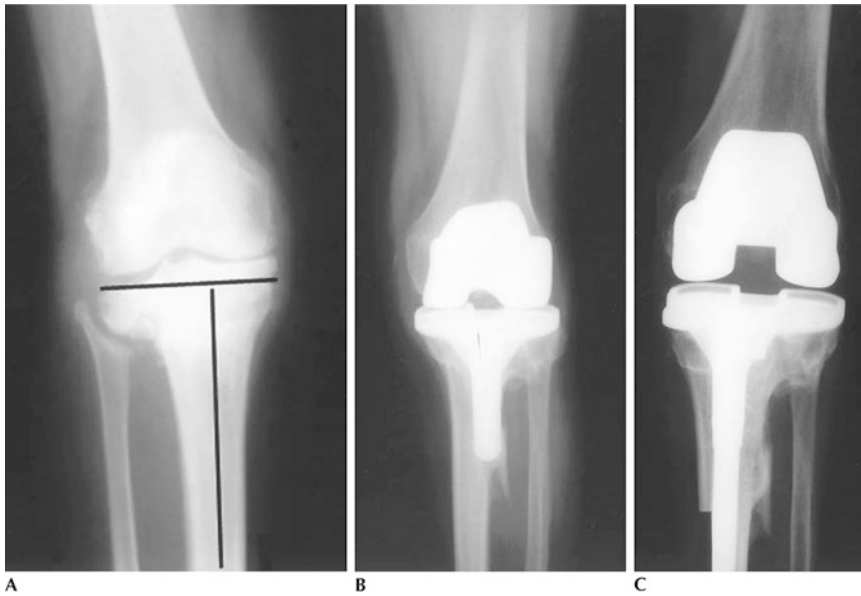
An AP radiograph showing an offset tibial shaft post HTO (a), an iatrogenic fracture of the proximal tibia with a standard tibial stem (b), and the revision TKA with an offset stem bypassing the cortical defect (c)
